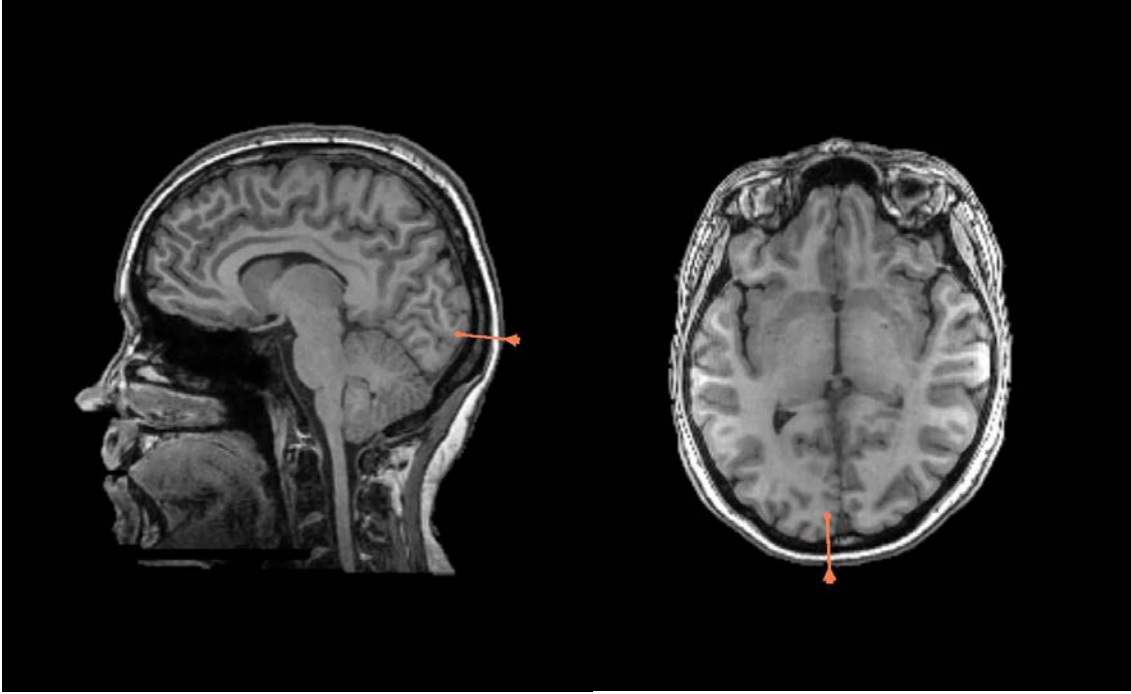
A stimulation location presented in a magnetic resonance image (MRI).
